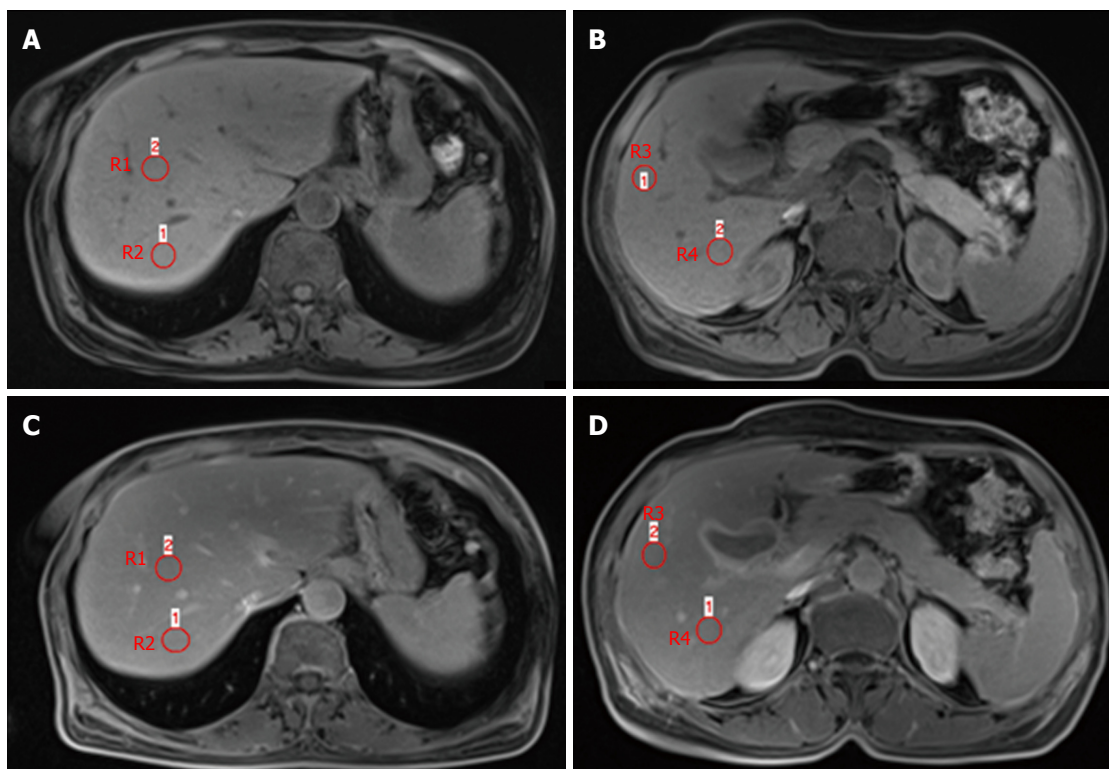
Transverse T1-vibe fat-suppressed (A and B) and T1-vibe fat-suppressed hepatocyte phase of Gd-BOPTA-enhanced magnetic resonance imaging (C and D) in a patient with S1 hepatic fibrosis. SI pre = $(R1 + R2 + R3 + R4)/4$ in A and B; SI post = $(R1 + R2 + R3 + R4)/4$ in C and D; RE = $(SI \text{ post} - SI \text{ pre})/SI \text{ pre}$.
